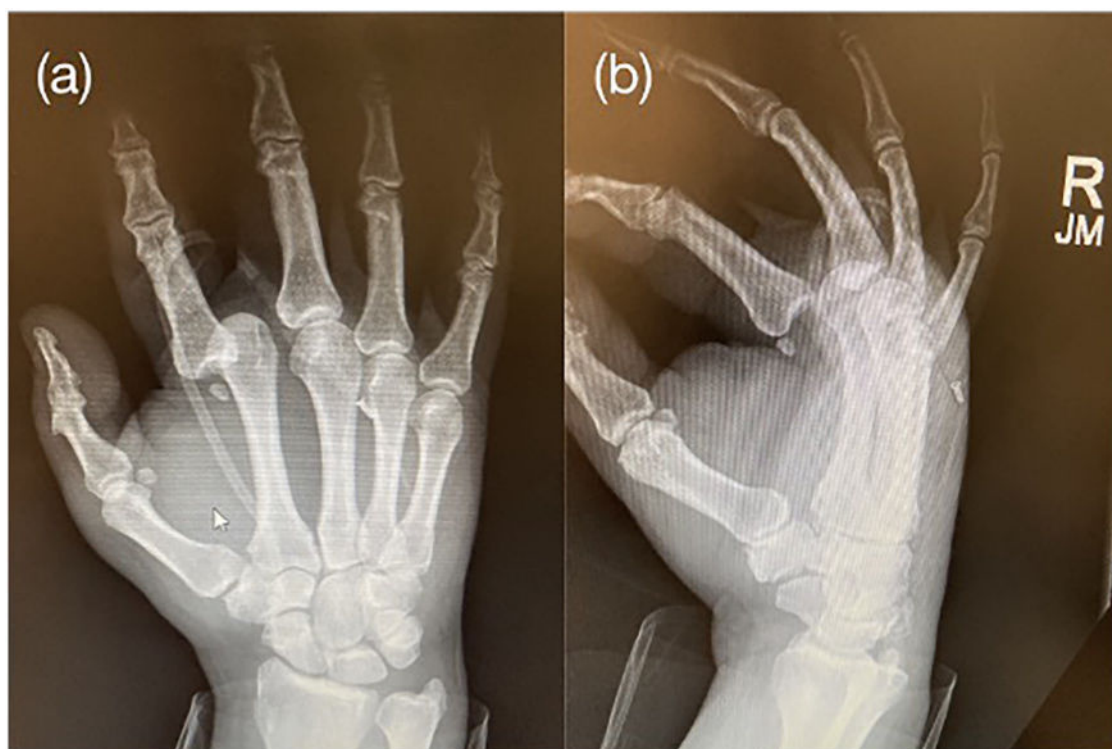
Preoperative right hand (a) posteroanterior radiograph and (b) lateral radiograph demonstrating closed volar dislocation of the right index finger at the metacarpophalangeal joint at the time of initial injury.
